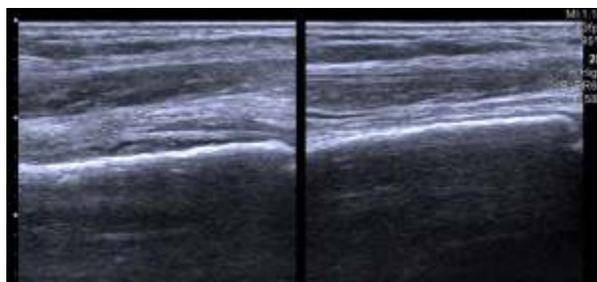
Initial ultrasound images obtained five days after onset showing periosteal reaction on the right distal tibia and a comparative image of the left tibia showing smooth bone.
